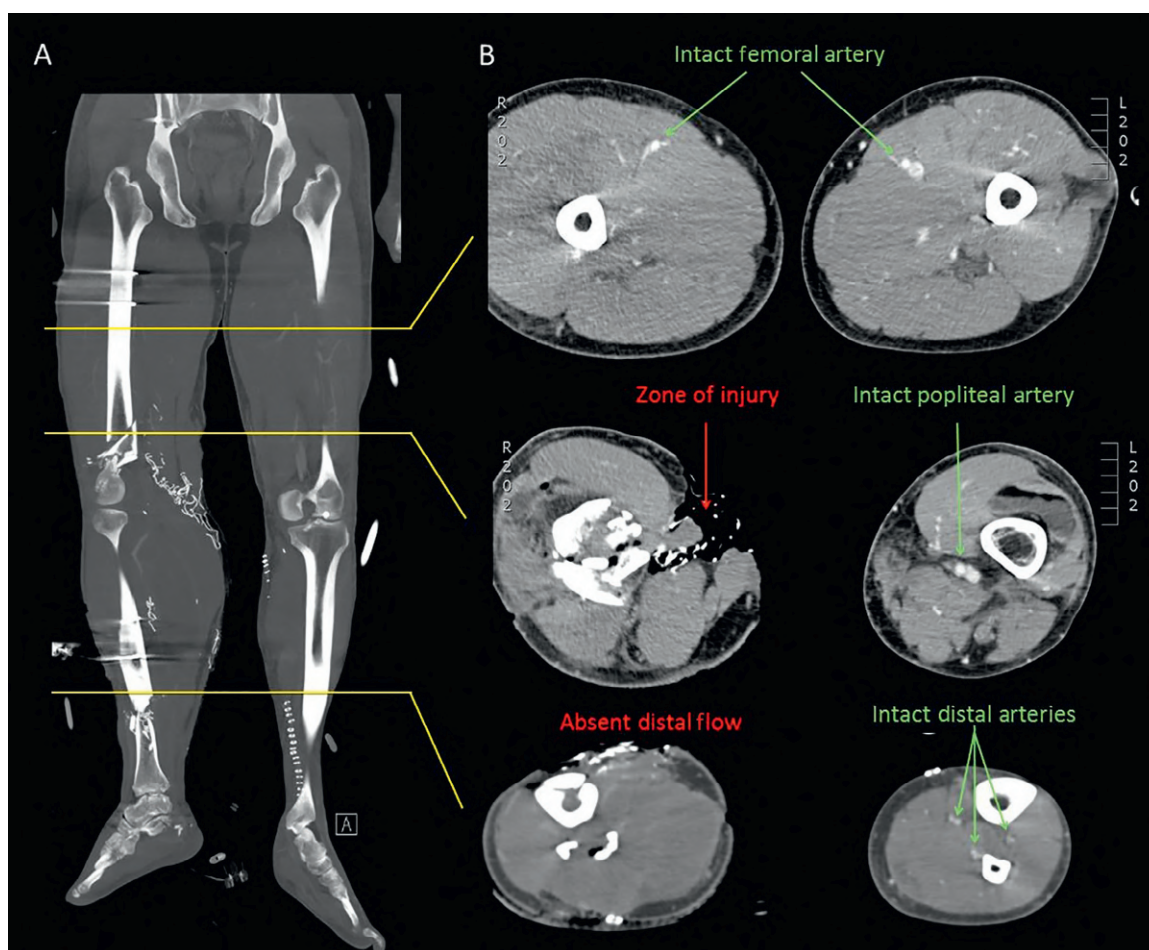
(A) Coronal computed tomography of lower extremity in a patient who sustained a blast injury. (B) Axial cross section of computed tomography angiography proximal to the zone of injury, at the zone of injury, and distal to the zone of injury. Note the absence of flow to the distal vasculature in the limb. Vascular repair in this patient was not successful, resulting in a transtibial amputation.
